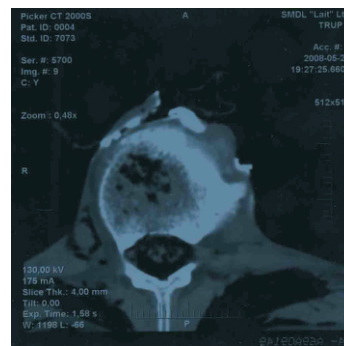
CT-scan in the retrocrural space showing cisterna chyli and main lymphatic tributaries
